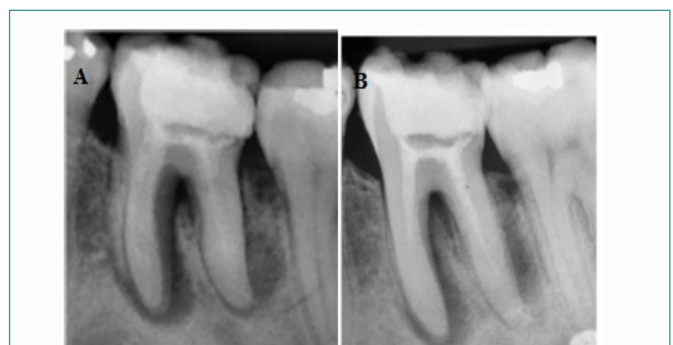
(A). Radiograph of tooth 36 after intracanal medication (14 days). (B). Change of intracanal medication (21 days).
